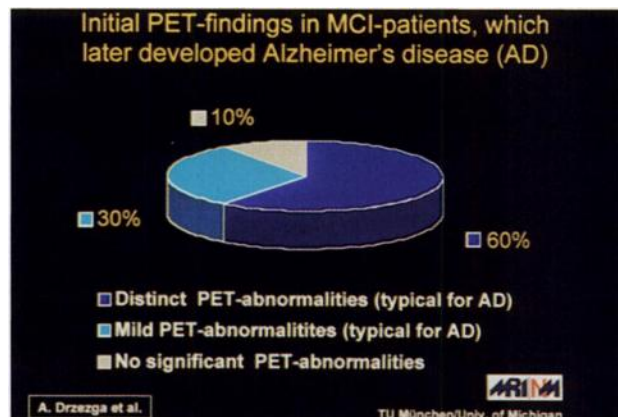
Initial FDG PET predicted subsequent development of Alzheimer's disease in patients with minor memory deficits (#250).
